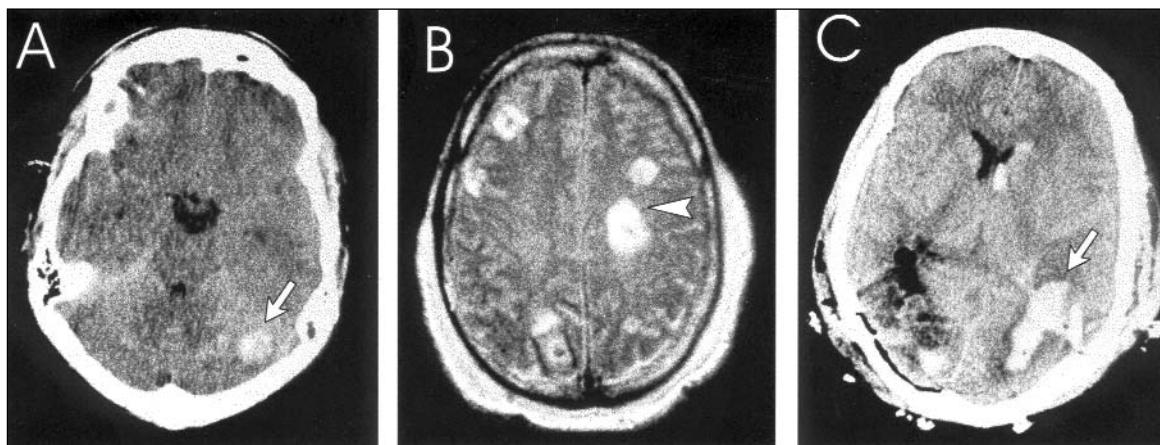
Neuroimaging showing an initial left cerebellar (A) intraparenchymal hemorrhage on CT scan. A subsequent MRI T2 weighted image revealed multiple lesions at day 3 post-admission (B). A CT scan following drain placement showed new hemorrhagic lesions (C).
